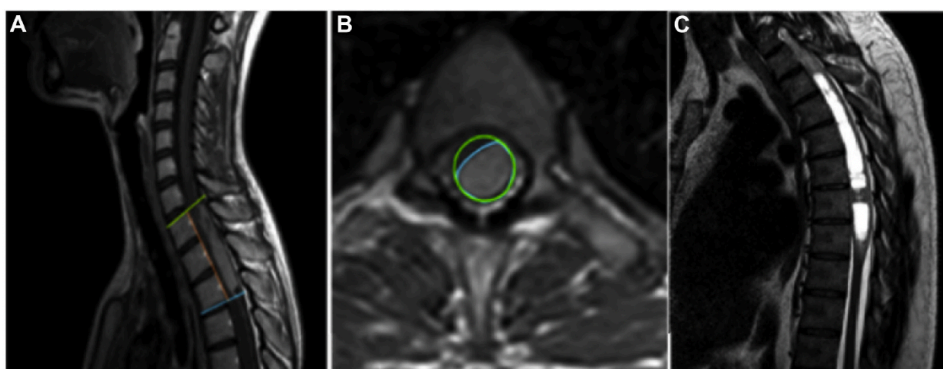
Magnetic resonance imaging (MRI) measurements. (A) Sagittal T1-weighted gadolinium-enhanced MRI used to measure the craniocaudal tumor extension (number of metamers). (B) Axial T1-weighted gadolinium-enhanced MRI slice in which the tumor presented the maximum axial extension. (C) Craniocaudal syrinx extension evaluated on sagittal T2-weighted MRI.
